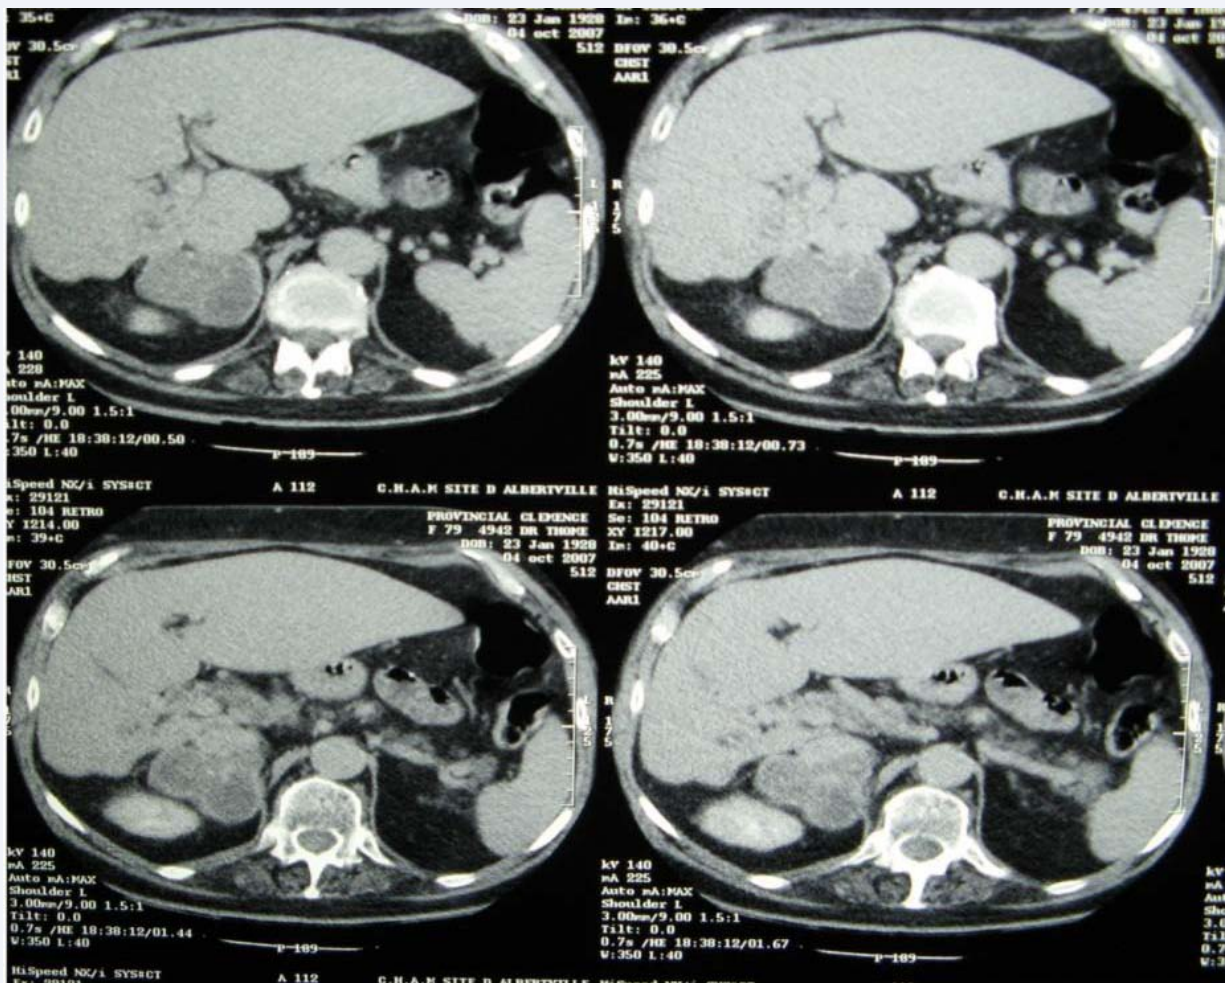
Abdominal CT without contrast injection: a mass adrenal right containing hypo dense central beaches.
